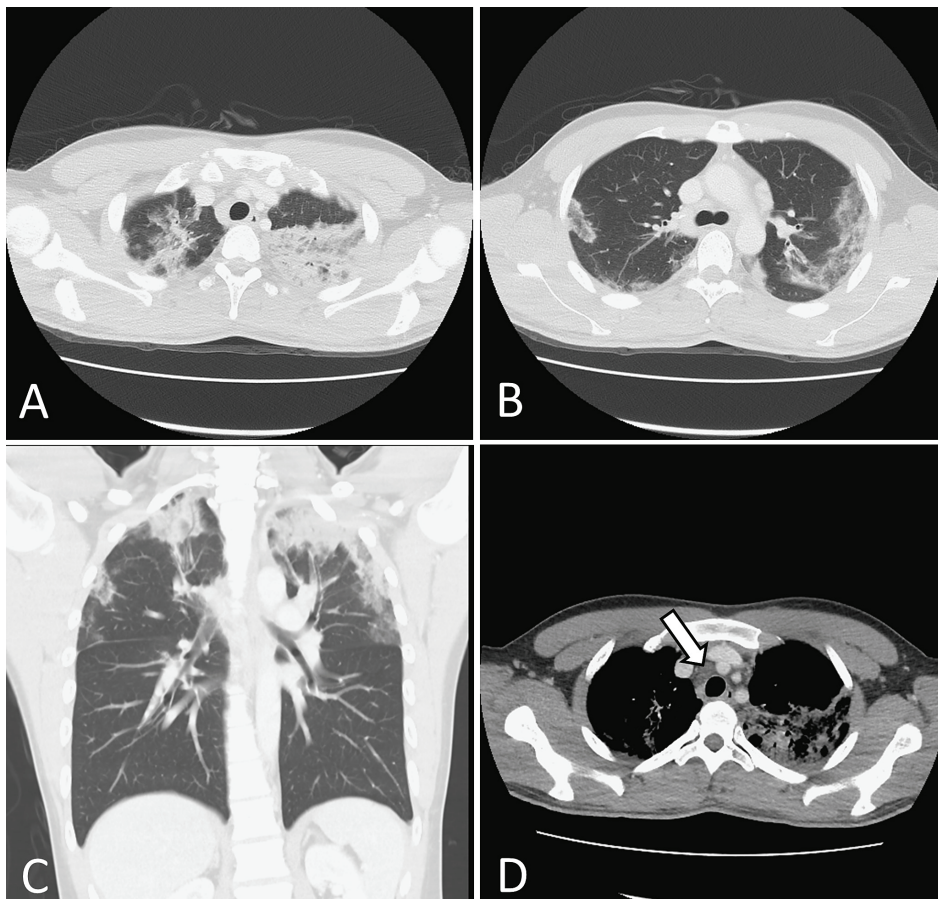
Computed Tomography of the Chest before Treatment.
